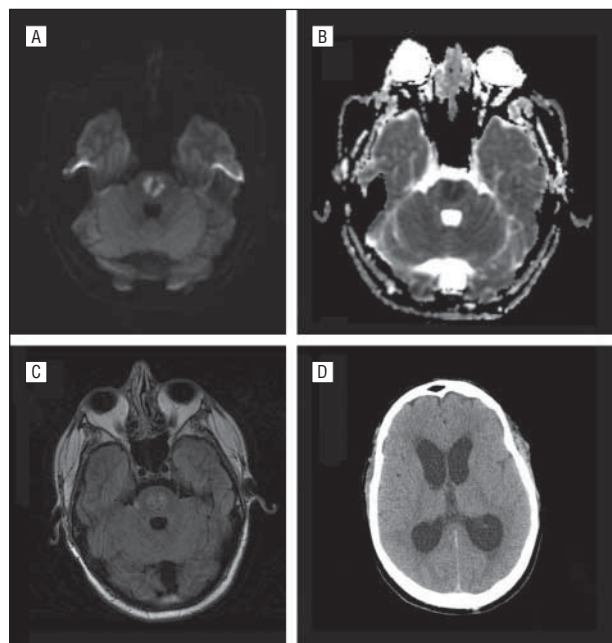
Brain images demonstrating acute bilateral pontine infarctions and hydrocephalus. A, Diffusion-weighted image. B, Corresponding apparent diffusion coefficient image. C, T2-weighted fluid-attenuated inversion recovery image. D, Computed tomography brain image at 4 weeks (preshunting) demonstrating hydrocephalus.
